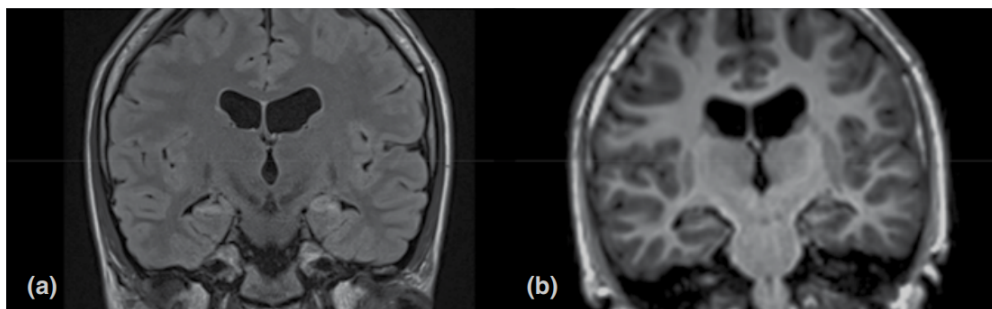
FLAIR (a) and T1 (b) with hyperintensity displayed in both mesial temporal lobes, characteristic of mesial temporal sclerosis(43), a condition that induces seizures. Adapted from (44).
